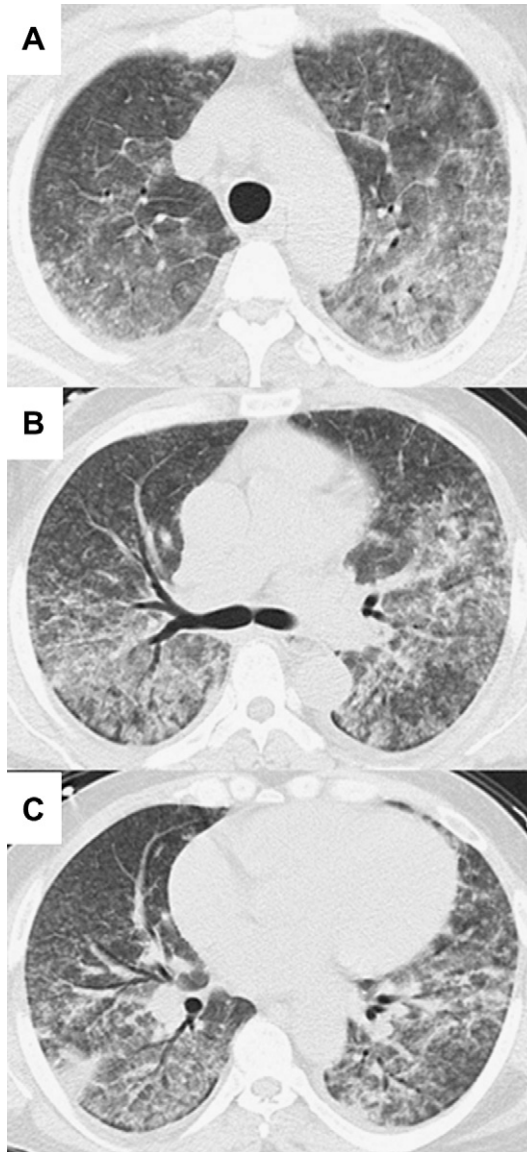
HRCT of a patient with acute HP showing bilateral ground-glass densities with centrilobular micronodular accentuation and minor consolidation. (A) Upper lobes, (B) middle lobes, (C) lower lobes.
